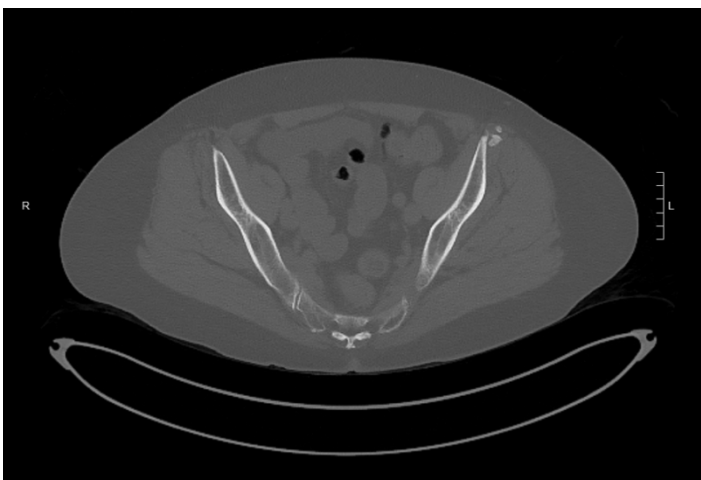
CT Pelvis June 2016 – moderate-sized exostosis or ossification (10x12x14 mm) attached to anterolateral aspect of iliac bone
